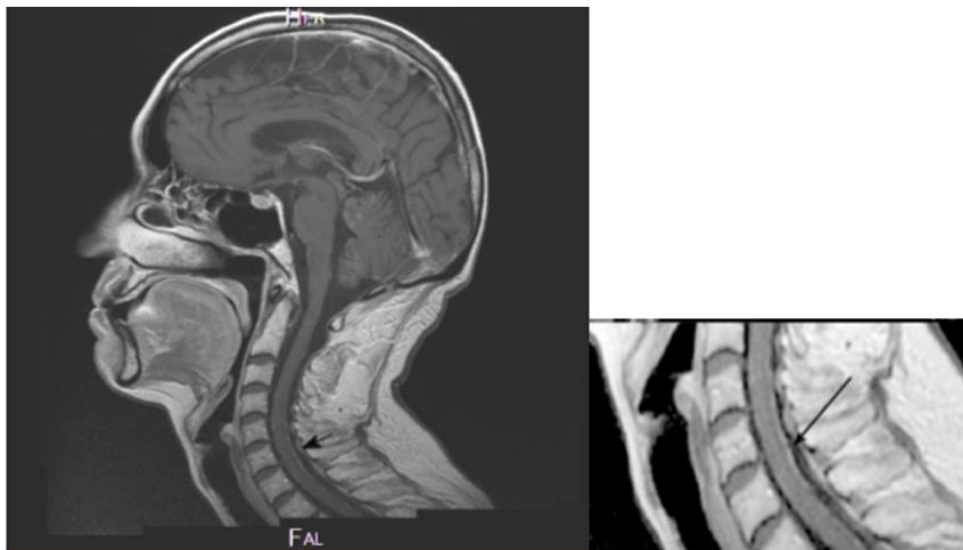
SAG T1 FLAIR+C MR postcontrast images of cervical spinal axis after 2 months of RT - leptomeningeal metastatic involvement of the spinal axis/cervical region
